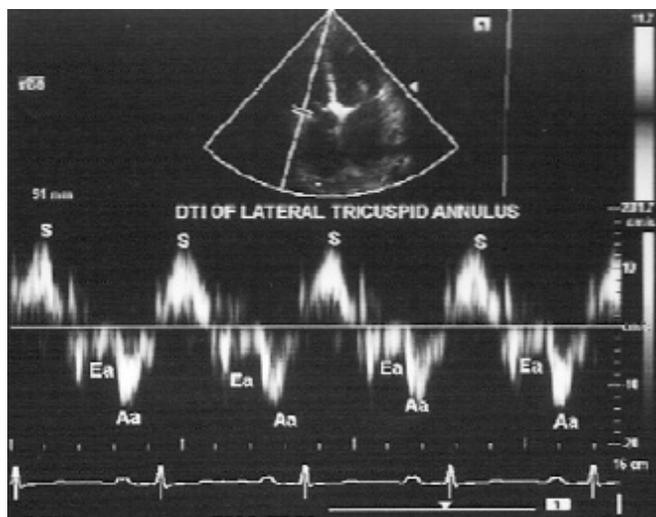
Tissue Doppler imaging of lateral tricuspid annulus showing diminished Ea velocity with normal Aa velocity.
